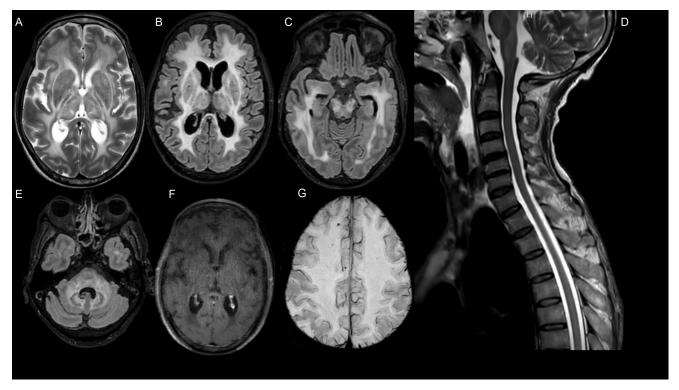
Magnetic resonance imaging of brain in 1A (T2 axial), 1B, 1C and 1 E (T2 FLAIR axial) showing bilateral symmetrical white matter hyperintensities including subcortical U fibres, the brainstem, the dentate nucleus and the middle cerebellar peduncle with sparing of the basal ganglia, MRI cervicothoractic spinal cord in 1 D (sagittal T2) showing normal spinal cord, MRI brain 1F (T1 axial with contrast) showing no enhancing lesions and 1G (susceptibility weighted imaging) showing no blooming.
